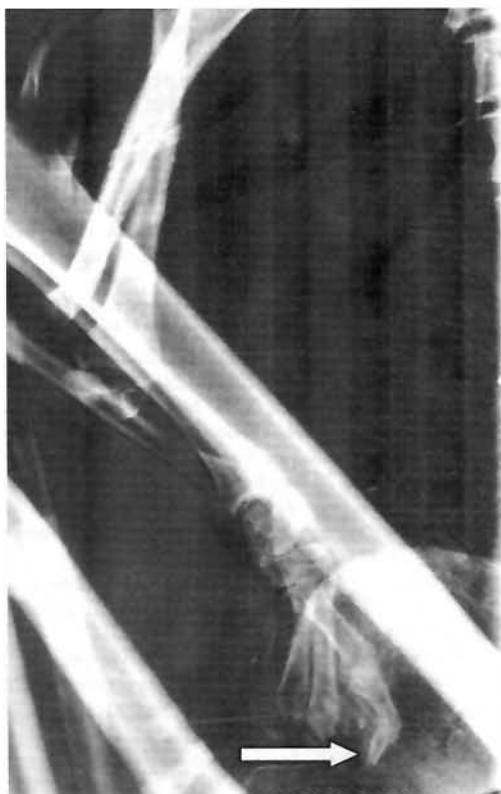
X-ray image of the amputated last digit of the left fifth finger.
